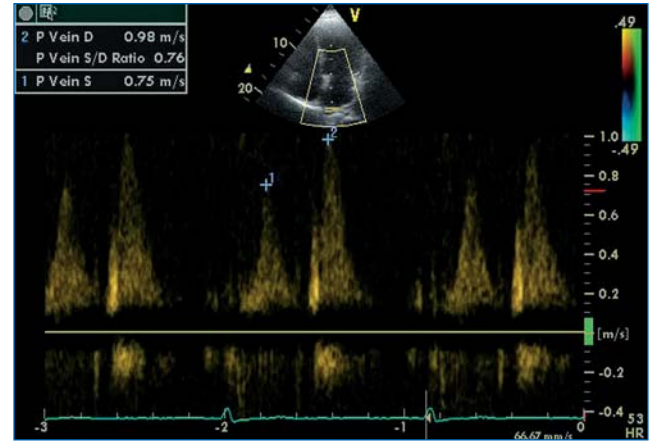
PW Doppler. Diminished systolic flow in pulmonary vein.
